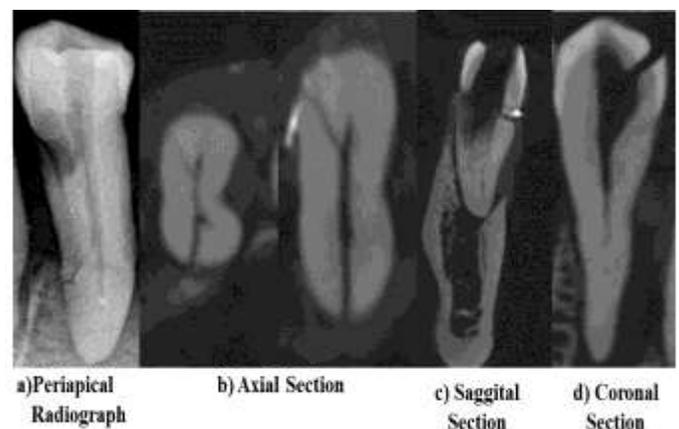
Periapical radiograph and various slices of CBCT
